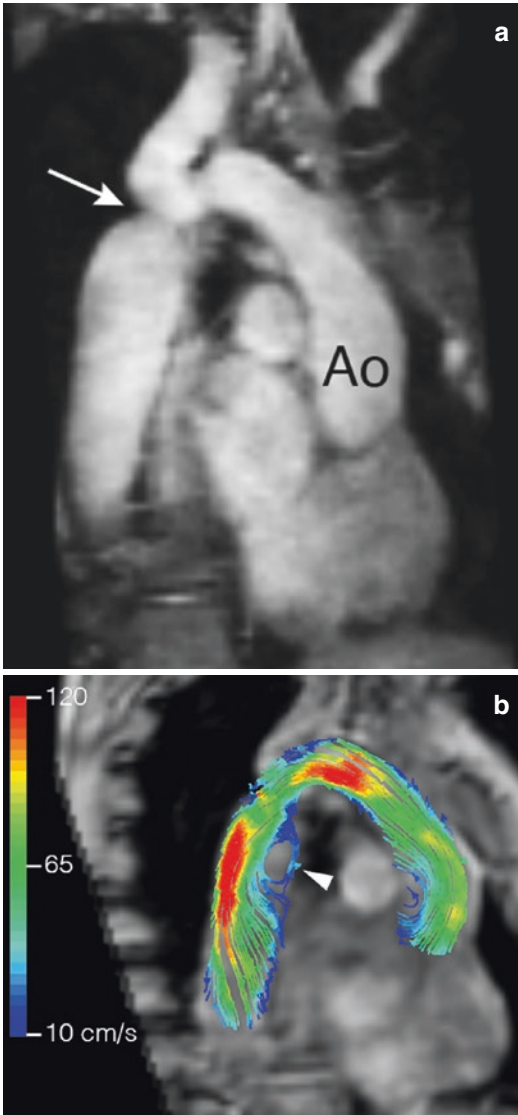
4D flow MRI of coarctation of the aorta. 29-year-old male with a coarctation of the aorta. In (a) a bright blood image of the aortic arch and proximal descending aorta with coarctation of the aorta (*arrow*). (b) shows the streamline visualisation with colour coding. Distal to the coarctation site, abnormal circular flow is present (*arrow-head*). Ao aorta. Figure from unravelling cardiovascular disease using four-dimensional flow cardiovascular magnetic resonance. (Adapted from Kamphuis et al. 2017)
